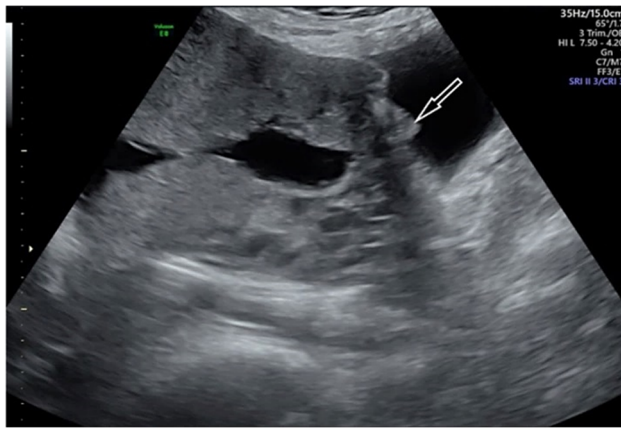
Transabdominal sonogram: placental bulge (white arrow) in pregnant woman, 28 years old, 33 GW, obstetrical history: two uterine Cesarean scars; present delivery way by Cesarean section for placenta praevia increta. GW: Gestational weeks.
